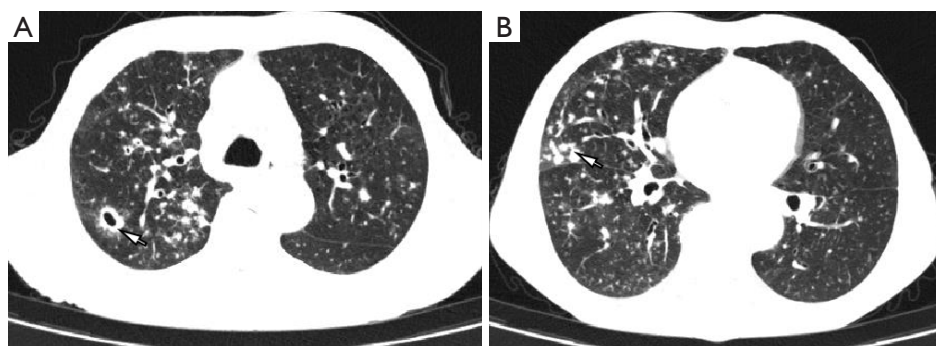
CT of a case of airway invasive pulmonary aspergillosis (male, 70 years old). (A) A thick-walled cavity and bronchial wall thickenings in the upper lobe of the right lung. The inner wall of the cavity is smooth, and halo signs (white arrow) are seen. Multiple nodules in both lungs are seen, some of which are distributed along the bronchi with blurred boundaries. (B) Impacted bronchi with dilatation (white arrow) are seen under the pleura in the upper lobe of the right lung. GGO shadows are seen around these lesions. CT, computed tomography; GGO, ground glass opacity.
